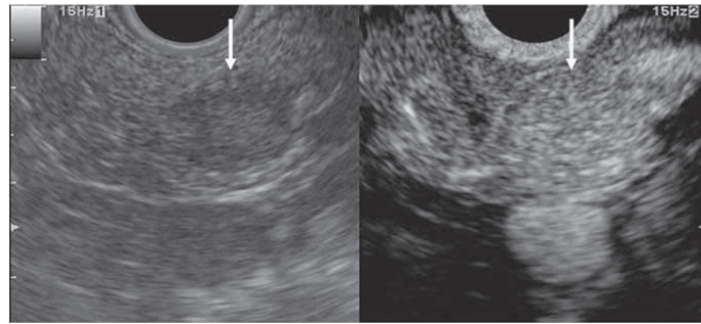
A typical example of a solid lesion with hyperenhancement (in this case, a neuroendocrine tumor of 10 mm in maximum diameter; see Supplementary Video S2 online). Conventional endoscopic ultrasonography (EUS; left) shows a hypoechoic mass (arrow) at the pancreas body. Contrast-enhanced harmonic endoscopic ultrasonography (CH-EUS; right) indicates that enhancement in the mass is higher than in the surrounding tissue.
